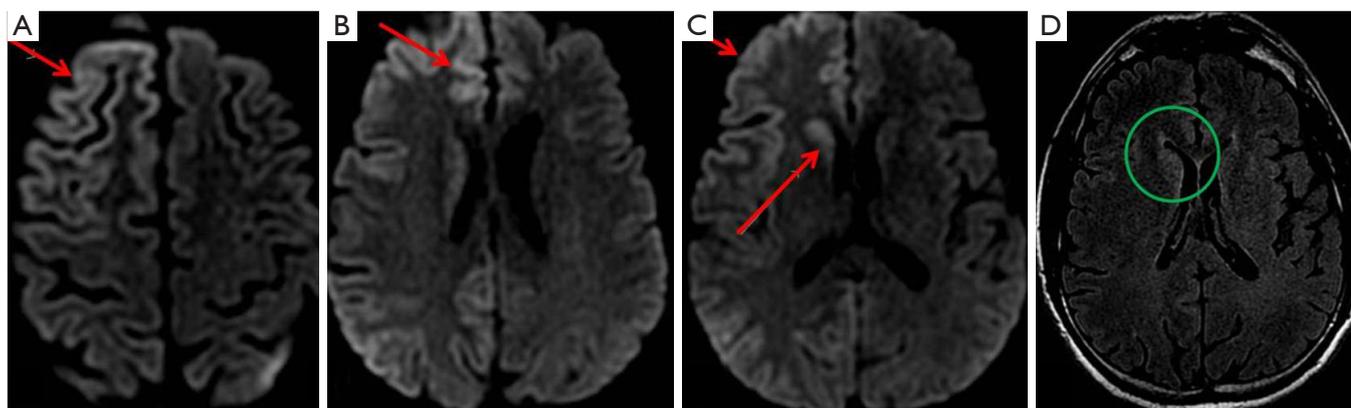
Diffusion-weighted axial images through the brain-vertex down (A-C) show hyperintense areas involving right frontal, temporal as well as occipital cortical gray matter (red arrows). Also note the involvement of caudate nucleus (red arrow). T2 fluid attenuated inversion recovery (FLAIR) sequence (D) shows in retrospect an area of increased signal in the caudate nucleus (green circle) which is very difficult to evaluate if there was no DWI. DWI, diffusion weighted imaging.
